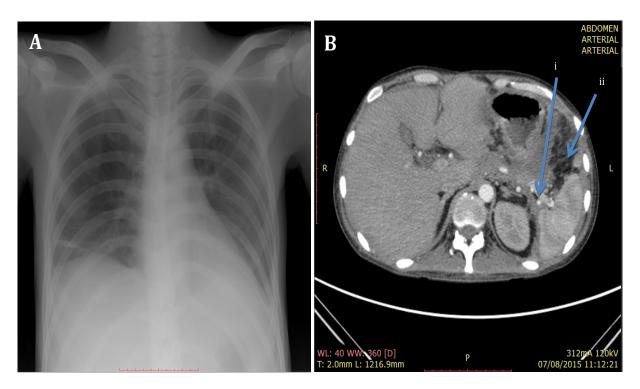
Chest X-Ray and abdominal MSCT of the melioidosis. (A). Bilateral lung consolidation was observed from the chest X-ray. (B). MSCT of the abdomen at level of splenic artey (i) and pancreas tail. MSCT showed signs of intraabdominal adhesion, small granulomas (ii).
